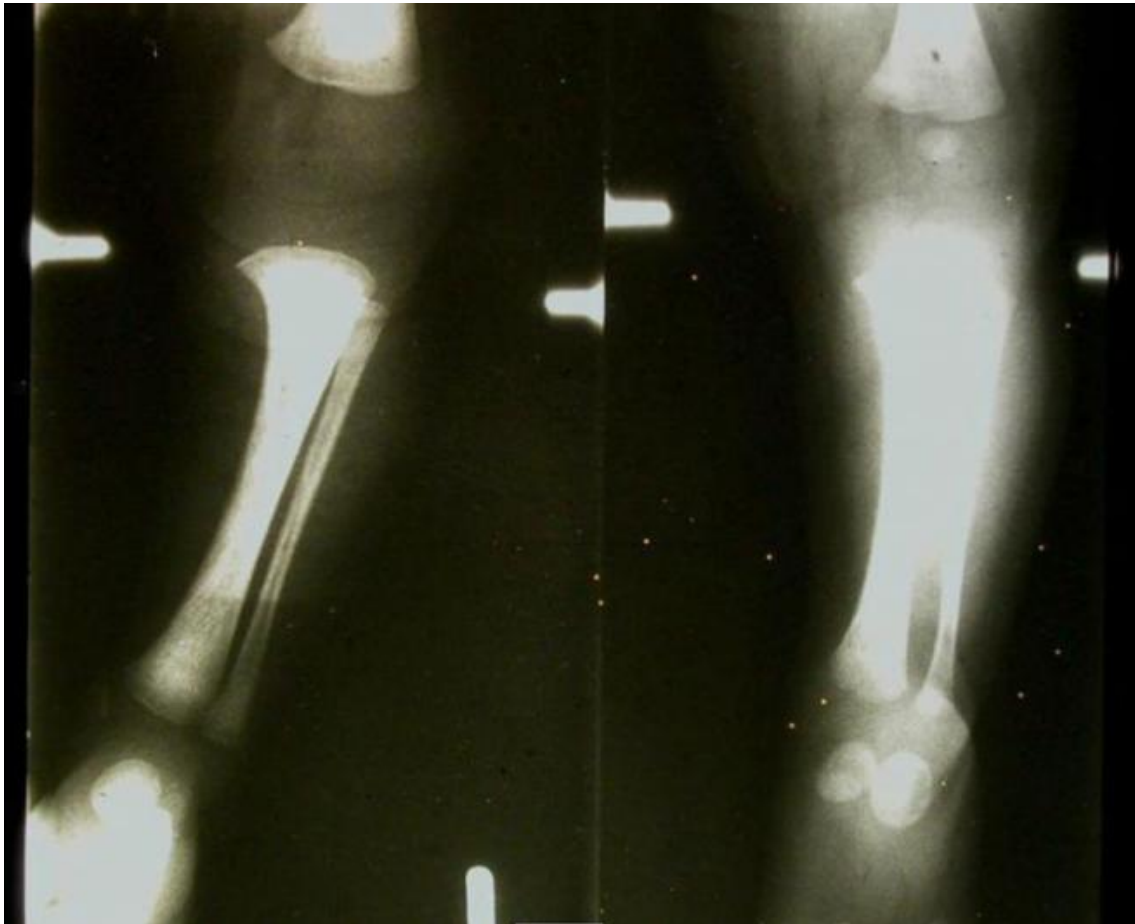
Radiograph of left lower extremity of two infants, (Left) Showing absence of distal femoral epiphysis, (Right) Distal femur showing presence of epiphysis in a normal child
